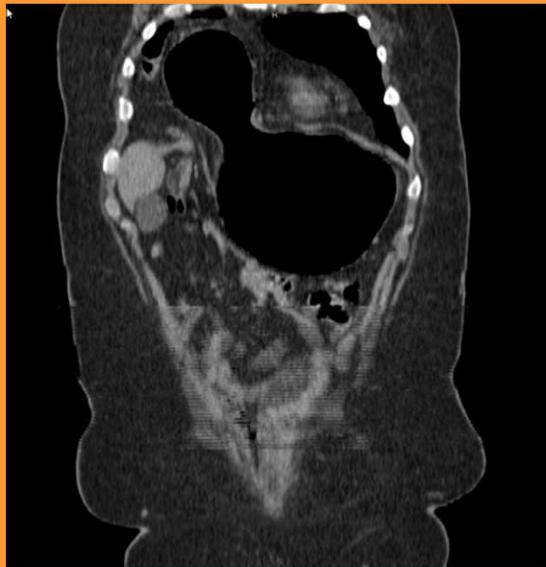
CT showing Morgagni hernia prior to initial repair with stomach antrum in right chest and stomach body under left diaphragm.
